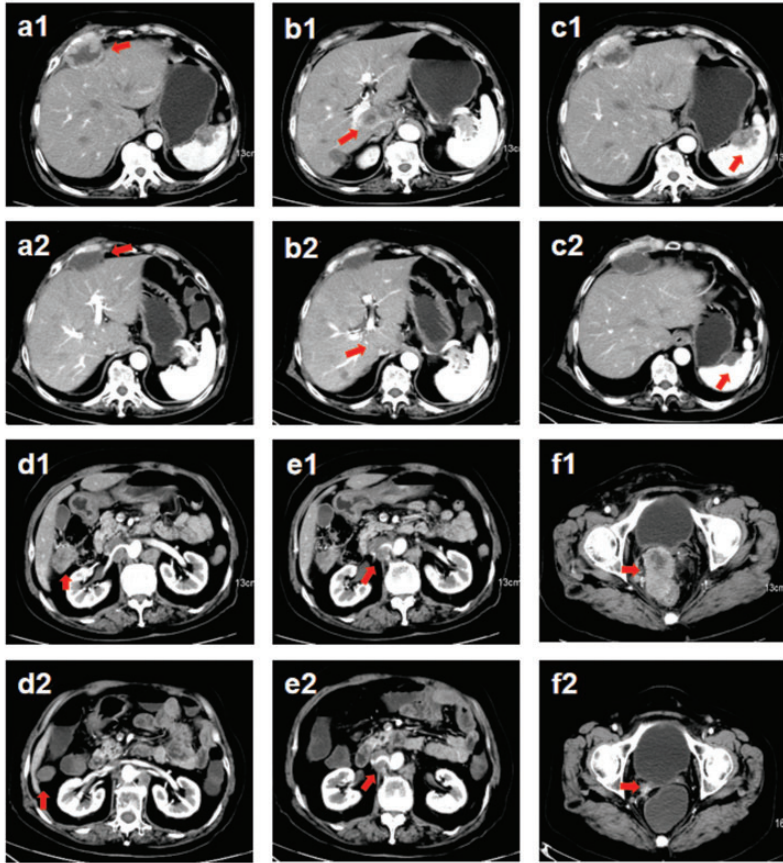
Computed tomography (CT) scans before and after anlotinib treatment. (a1-f1) Extensive metastases (arrows) were evident on CT scans before anlotinib treatment (November 21, 2019). (a2-f2) Metastatic lesions were reduced on CT scans after six cycles of anlotinib treatment (March 28, 2020).
